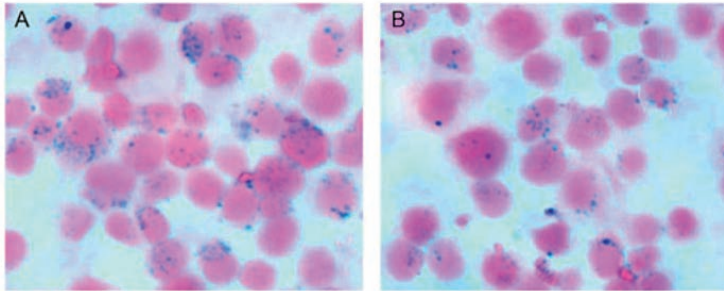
BN175 cells and labeling super paramagnetic iron oxide particles (SPIO) particles (image acquired at 400 x magnification), prepared for MRI measurements. The typical vesicular perinuclear distribution of SPIO can be observed as often reported following endocytosis. No excess SPIO are observable in the extracellular space. A Cytospin slide after labeling; B cytospin slide 48 h after labeling.
